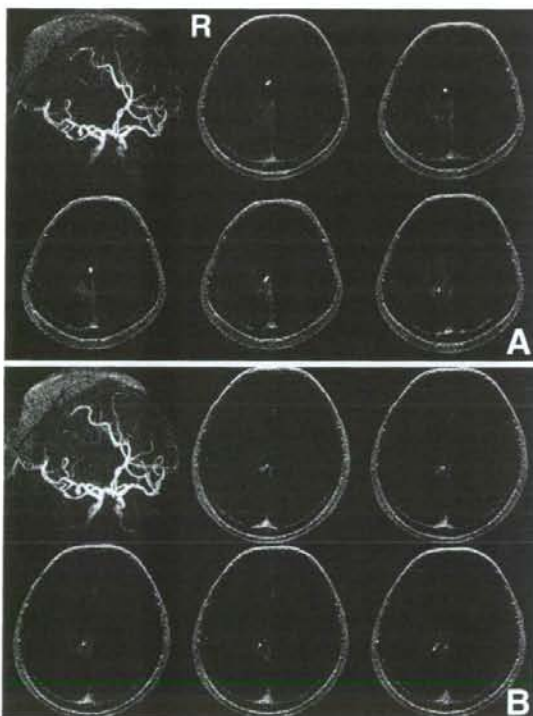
Case 2, a 73-year-old woman with atypical meningioma. The green line was drawn on the anterior cerebral artery (ACA) on the maximum intensity projection image in three-dimensional space and the location of the green line was shown simultaneously on axial spoiled gradient recalled magnetic resonance images as a red point. The distal branches of the right ACA entered the tumor anteriorly (A) and inferiorly (B), but did not penetrate the tumor.
